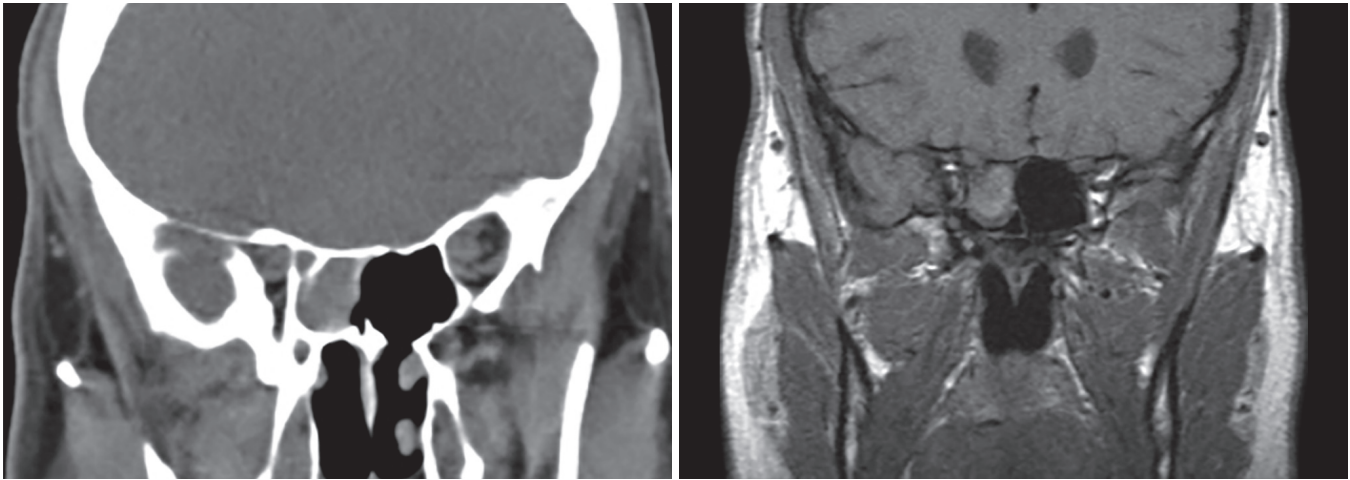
Preoperative computed tomographic imaging and magnetic resonance imaging of an isolated right sphenoid inverting papilloma.
